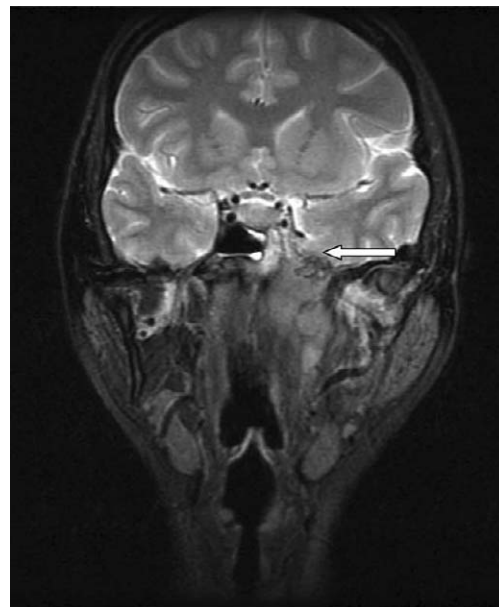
Coronal T2-weighted image depicts skull base tumoral invasion, which is of moderately low signal intensity (arrow).
